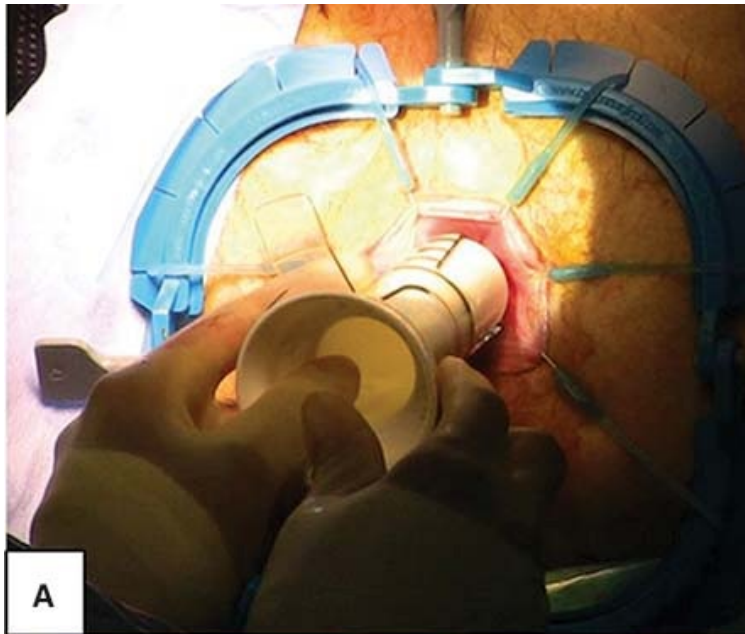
A Lone Star retractor (Cooper Surgical, Trumbull, CT) and plastic anoscopy (A) are used to facilitate transanal placement of a pursestring suture to occlude the rectum below low-lying rectal tumors (B).
